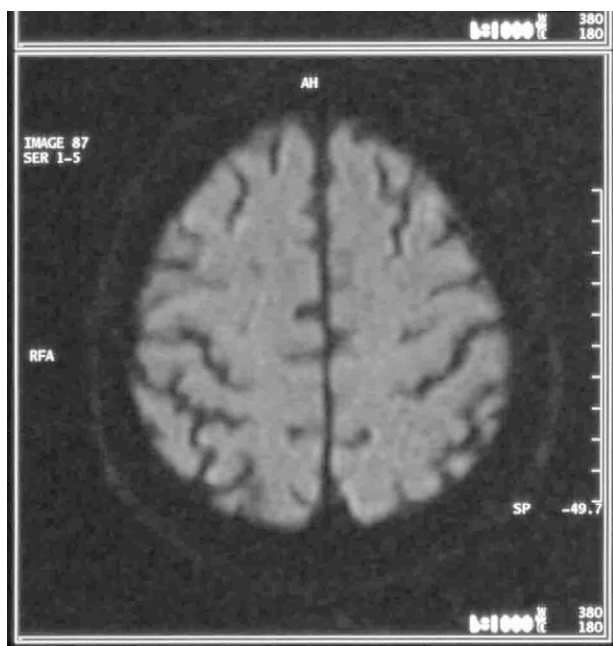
DWI before CEA in a patient with symptomatic high-grade stenosis of the left carotid artery.
